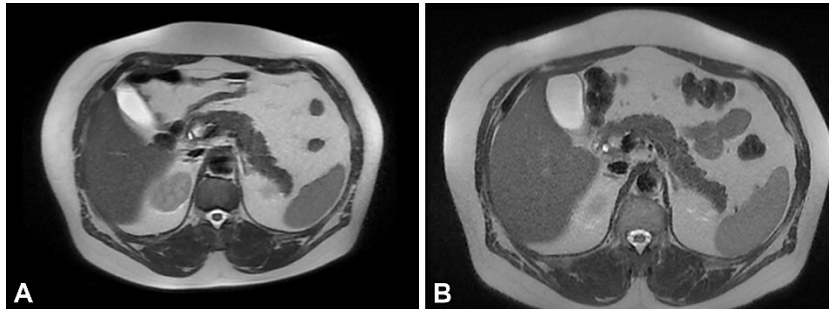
(A) Before procedure T1-weighted MRI imaging showing pancreatic head lesion; (B) Post EUS-RFA T1-weighted MRI imaging showing pancreatic lesion decreasing in size. EUS: Endoscopic ultrasound; MRI: Magnetic resonance imaging; RFA: Radiofrequency ablation.
